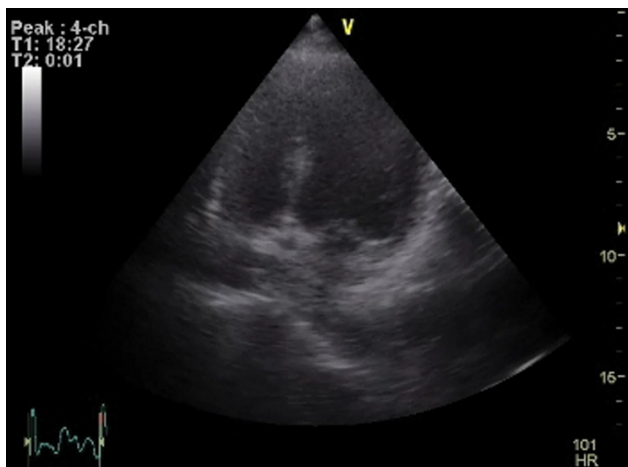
Stress echocardiogram during ventricular tachycardia, LVlDd: 6.80 cm, LVED: 69.93 ml, LVlDs: 5.41 cm, LVESV: 29.35 ml, LVEF: 58.03%.
